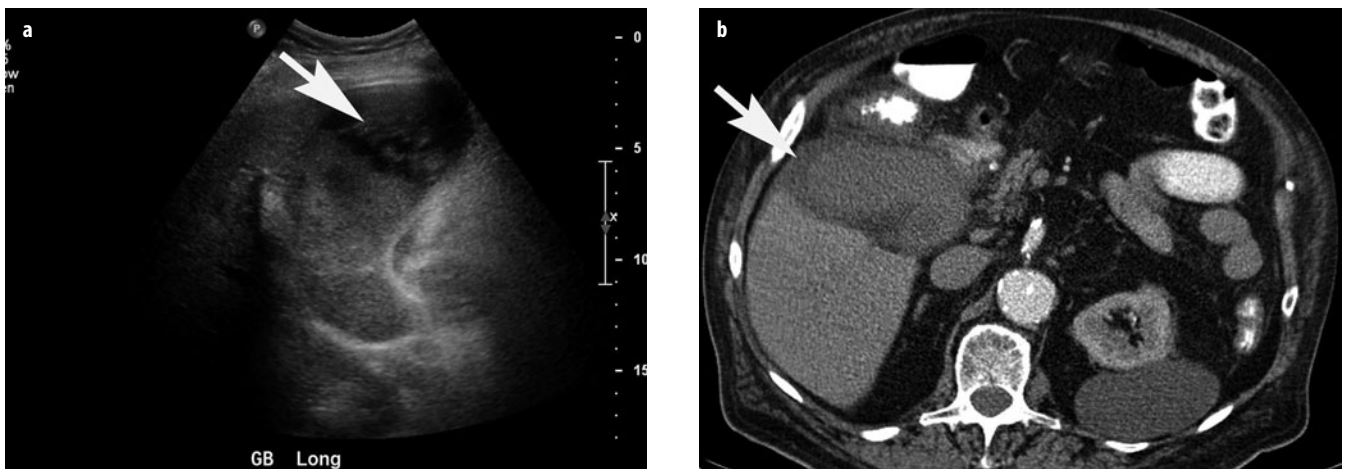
a, b. Gangrenous cholecystitis. a Longitudinal ultrasound (US) shows a distended gallbladder containing sludge and intraluminal membranes (*arrow*). b Contrast-enhanced computed tomography (CT) using intravenously and orally administered contrast media shows nonenhancing, thick gallbladder wall (*arrow*). The high attenuation in the gallbladder lumen represents blood products
